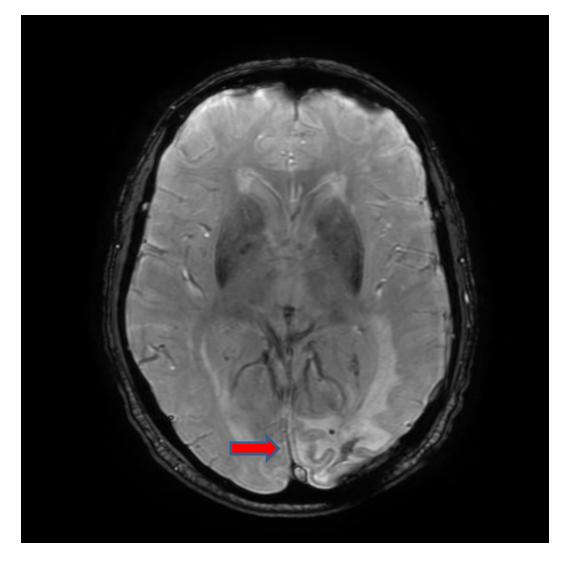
10 months post craniotomy MRI.
